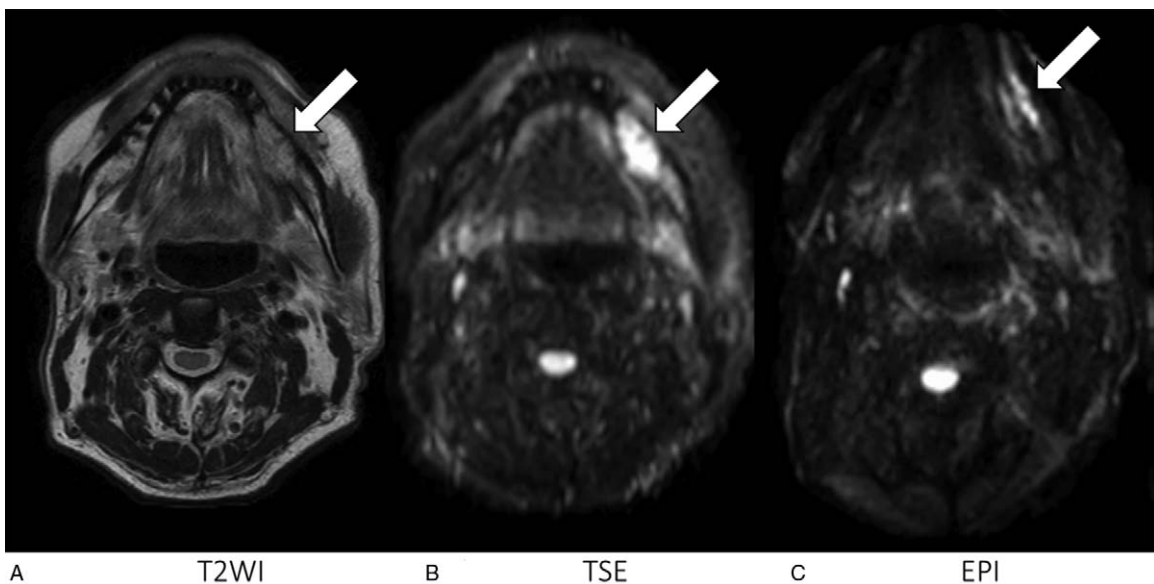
MRI images (A: T2WI image, B: TSE-DWI image, C: EPI-DWI) of a 79-year-old man with gingival cancer. An opacified tumor (arrows) is detectable on the TSE-DWI image (B), whereas it is difficult to identify on the EPI-DWI image (C).
